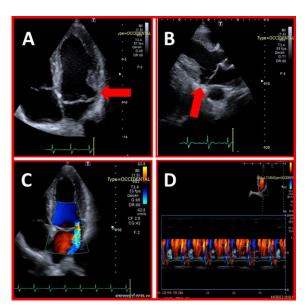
Panel A and B, Trans-thoracic apical 4 chamber and parasternal long axis view showing Mitral annular disjunction (7.7 mm). Panel C, mitral regurgitation jet. Panel D color M-mode showing mid to late mitral regurgitation
